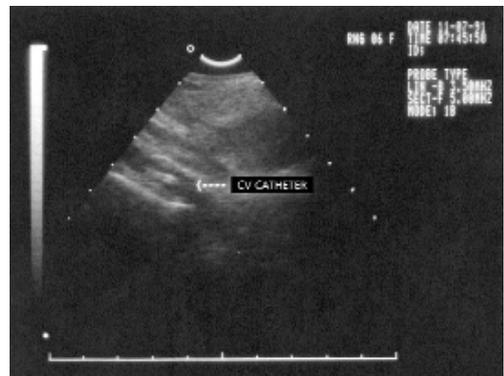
Ultrasonographic transversal presentation of v. anonyma (convex transducer; 5 MHz). Double echo in vein presents central venous catheter.
